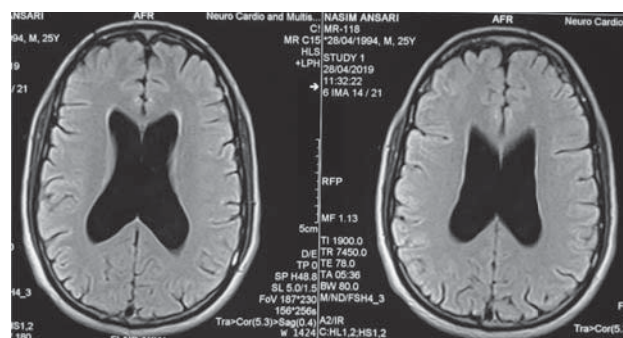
MRI brain with T1 axial cuts showing hydrocephalus.
